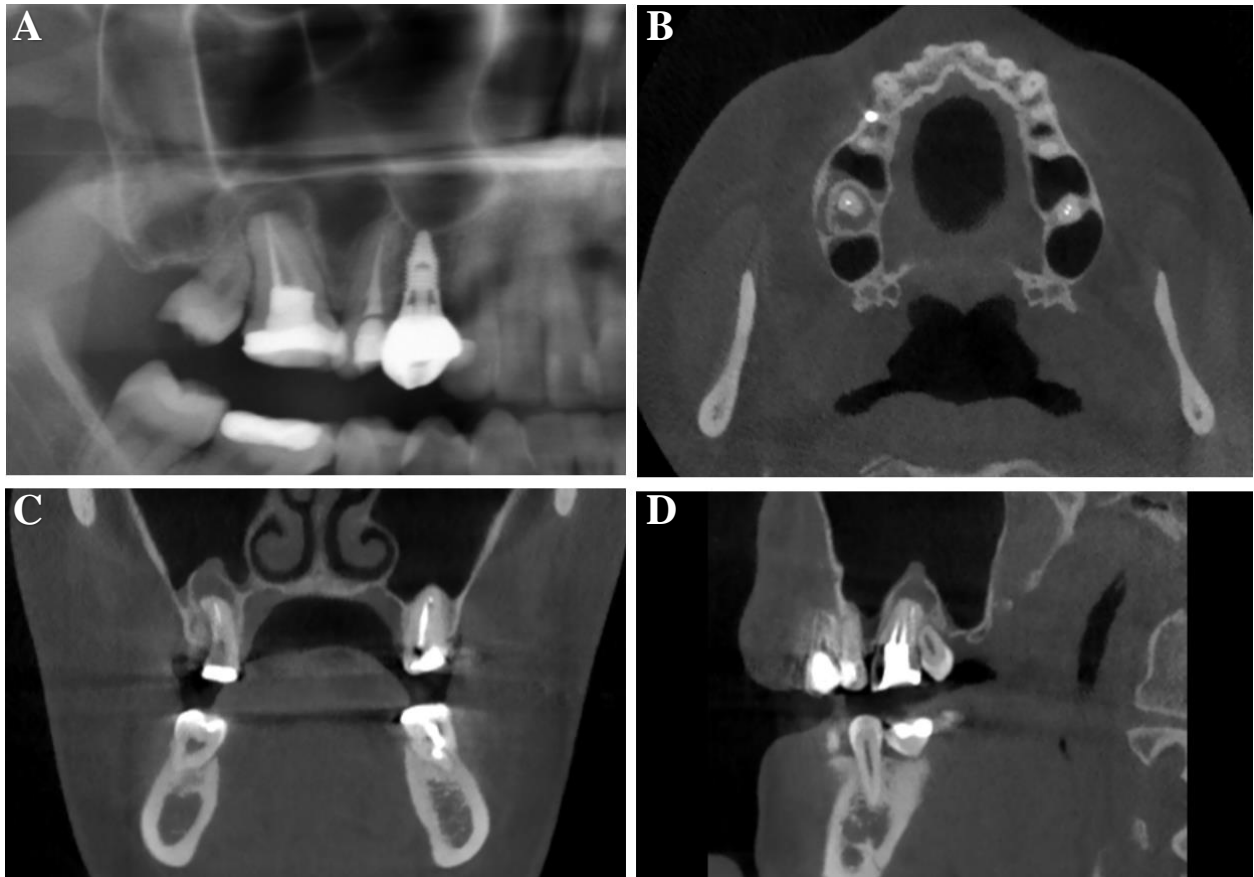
ROI tooth 15. A, cropped PAN depicting a well-defined, corticated, periapical radiolucency at restored tooth 15 causing elevation of the maxillary sinus floor. Partial opacification of the maxillary sinus is observed. CBCT slices: B, axial, C, coronal, and D, sagittal view. Showing a well-defined periapical low-density with breaching of the maxillary sinus floor. Mucosal reaction in the right maxillary sinus can be observed.
